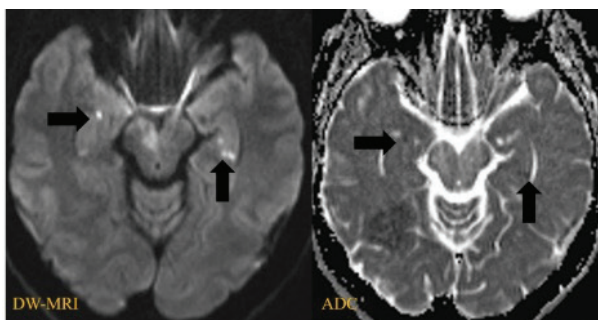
DW-MRI shows areas with restricted diffusion in both hippocampi (arrows). There are hypointensities in the corresponding areas on ADC (arrows)
